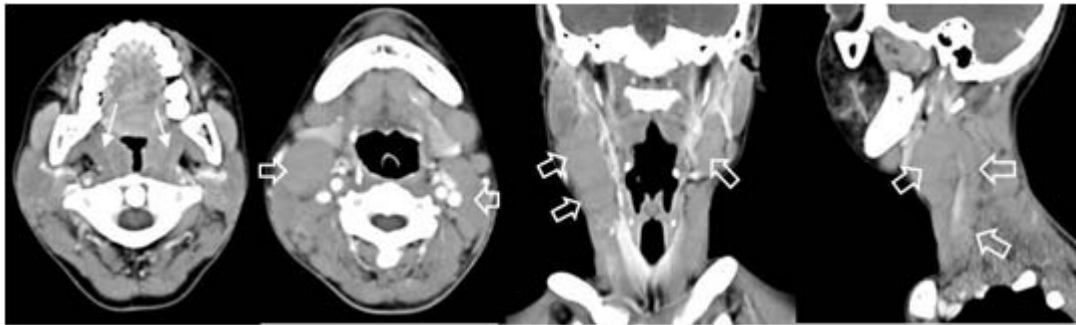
Combined nodal and extranodal lymphatic disease. Enhanced axial, coronal and sagittal CT scan showed bilateral tonsillar masses (arrow) and bilateral cervical lymphadenopathy at level IB, II, III, IV and V (open arrow).
